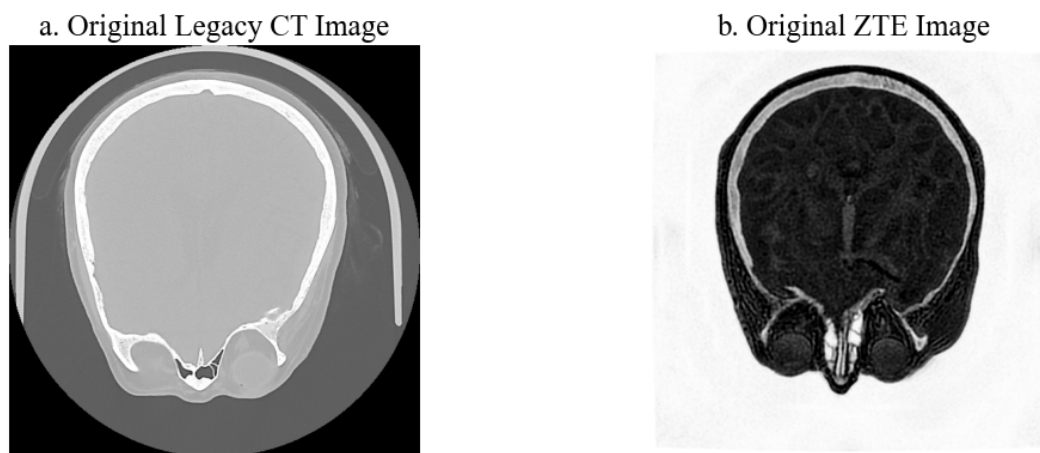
Raw images before processing. (a) Unconventional CT and (b) normal ZTE images of one patient before any preprocessing or registration.
